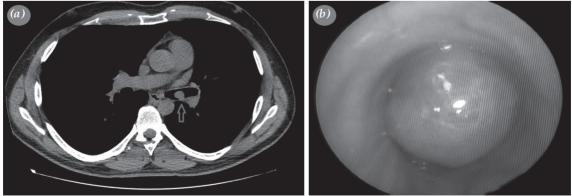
(a) Axial computed tomography image of endobronchial mass (gray arrow shows mass) and (b) bronchoscopic view of mass.
